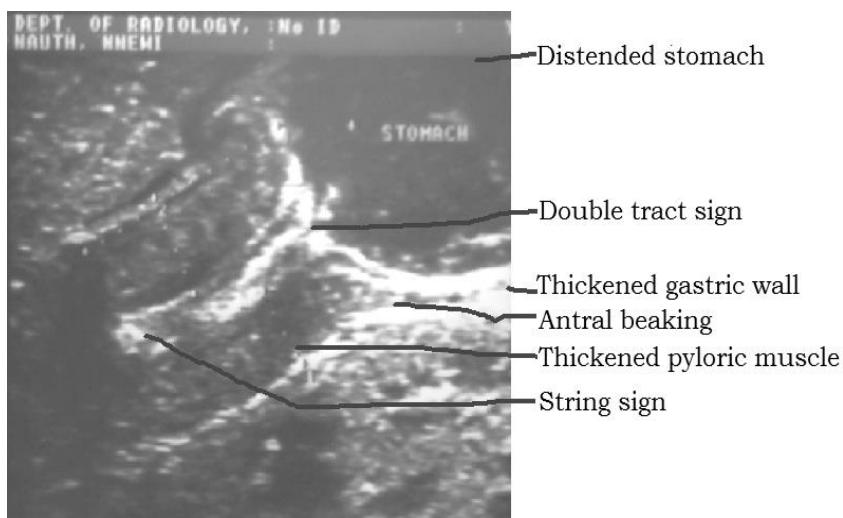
Sonogram showing grossly dilated stomach and narrowed pyloric canal with thickened elongated muscles in infantile hypertrophic pyloric stenosis.
